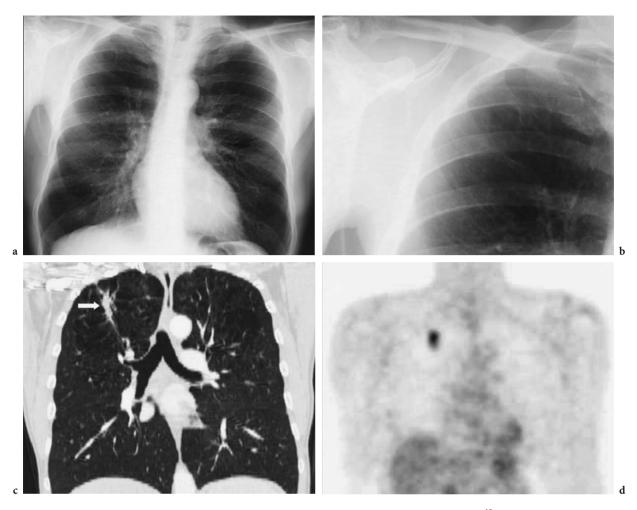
MDCT is more sensitive than chest radiography at detecting early lung cancer. ¹⁸F-Deoxyglucose positron emission tomography (FDG-PET) can be used as an additional tool for lung nodule characterization. A 70-year old man, heavy smoker, underwent a chest radiograph and MDCT for lung cancer screening. a Postero-anterior chest radiography did not reveal any suspicious lung nodule. b A close-up of the right upper lobe did not show any lung lesion even retrospectively. c Frontal reformatted chest CT revealed a spiculated lung nodule (*arrow*) consistent with lung cancer. No mediastinal enlarged lymph node was present. d FDG-PET demonstrated an intense uptake in the right upper mass consistent with a lung tumour. The TNM staging was $T_1N_0M_0$ at the time of diagnosis
